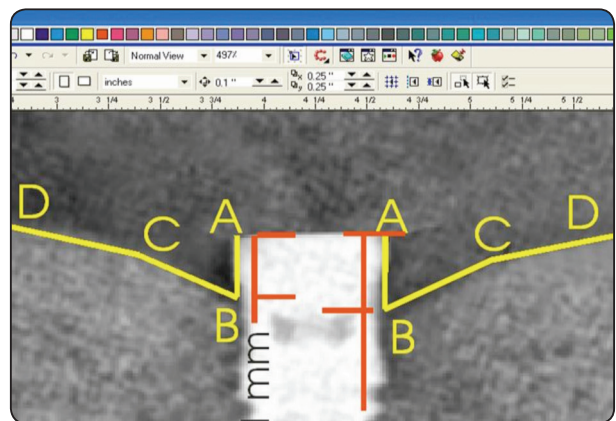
Print screen of Corel Draw computer program during measuring the radiographic bone loss guided by lines and reference points marked on the screened peri-apical radiograph.
